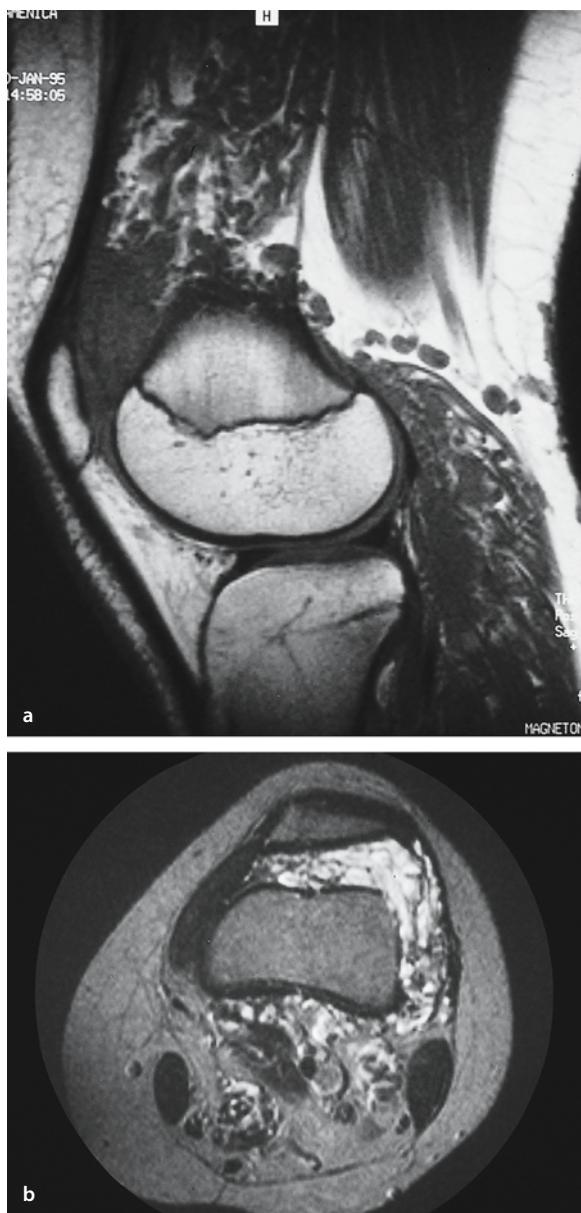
a, b. Synovial hemangioma of the knee. a Sagittal T1-weighted MR image. b Axial T2-weighted MR image. A multilobular inhomogeneous lesion involving both the suprapatellar bursa and the extra-articular fatty tissue and muscles is seen. The lesion is isointense to muscle on T1-weighted images and a large draining vessel is seen in the popliteal fossa. Axial T2-weighted images show a lesion of high signal intensity. There is no joint effusion
